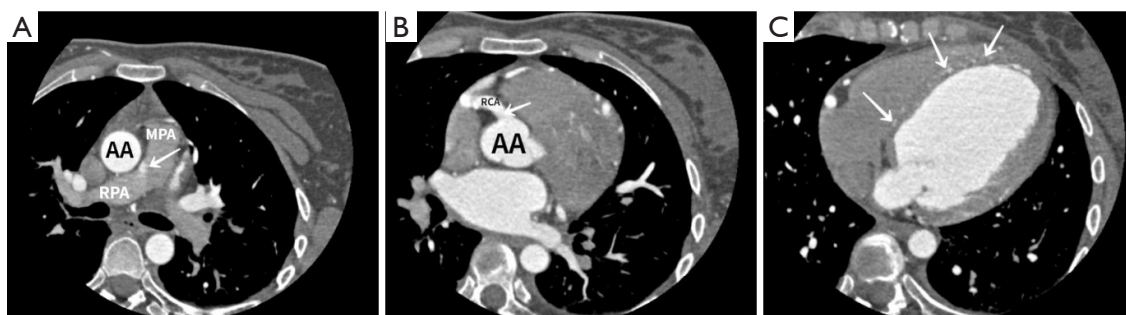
Computed tomography angiography of infant-type anomalous left coronary artery arising from the pulmonary artery. (A) A short-axis image shows the left coronary artery (white arrow) originating from the right wall of the main pulmonary artery. (B) A short-axis image shows the right coronary artery originating from the aorta with an enlarged lumen (white arrow). (C) A short-axis image shows multiple collateral circulations (white arrows) in the interventricular septum. MPA, main pulmonary artery; RPA, right pulmonary artery; AA, ascending aorta; RCA, right coronary artery.
